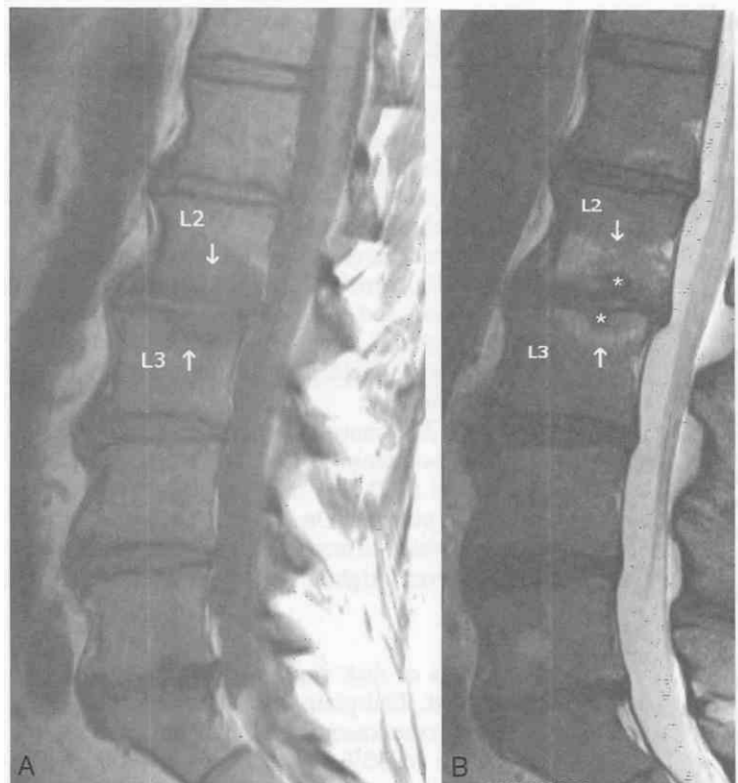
Type I end-plate changes. A, T1-weighted MR image shows hypointensity of the inferior L2 and superior L3 end plates (*arrows*). B, T2-weighted MR image shows that the end plates have become hyperintense. This is the earliest stage of disk degeneration. The lower lumbar disks are dark on the T2-weighted scan because they have become dehydrated from degeneration. Note small Schmorl's nodes (*asterisks*).
